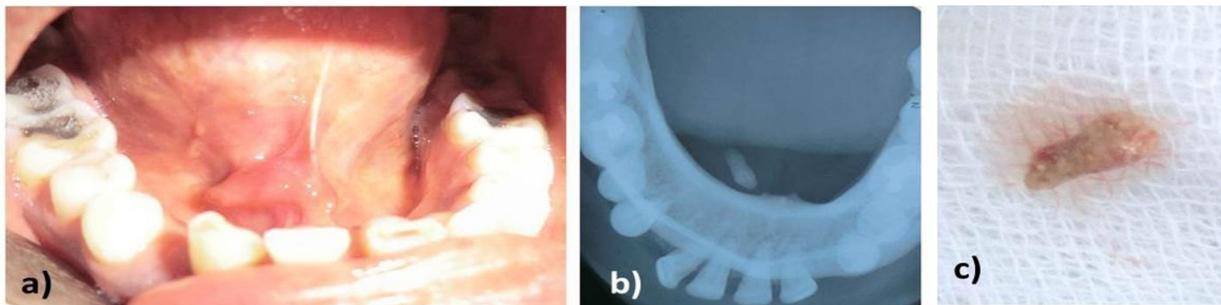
a) Right submandibular sialolithiasis in Wharton's duct, b) Occlusal radiograph showing typical radiographic appearance of stone in the submandibular duct, c) 9mm sialolith
